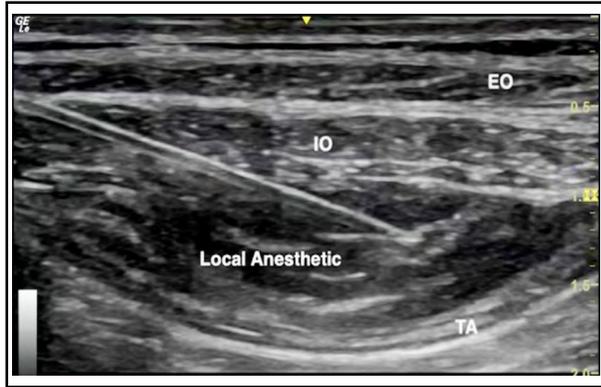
Ultrasound guided TAPB (EO: external oblique, IO: internal oblique, TA: transversus abdominis).
